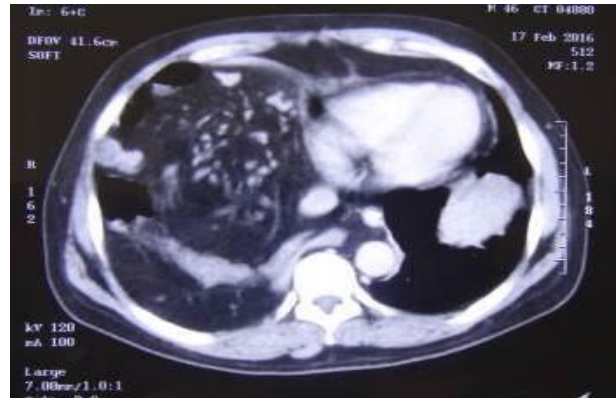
Contrast-enhanced computed tomography of thorax showing displacement of the abdominal viscera into the right thoracic cavity.
